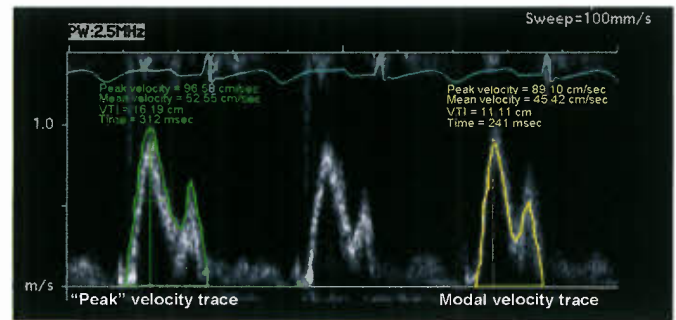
Mitral valve Doppler spectral profile demonstrating the difference between a “peak” velocity trace (green on the left waveform) and modal velocity trace (yellow on the right waveform). The “peak” velocity trace follows the outside edge of the Doppler spectral contour while the modal velocity trace follows the midline of the contour. “Peak” velocity traces are used to obtain peak and mean pressure gradients across valves and orifices. Modal velocity traces are used in the continuity equation and in calculation of cardiac output. Note that there can be a potentially large difference in the values obtained from a “peak” and modal velocity trace. (e.g., 31% difference in the two velocity time integrals (VTI) in this case)
